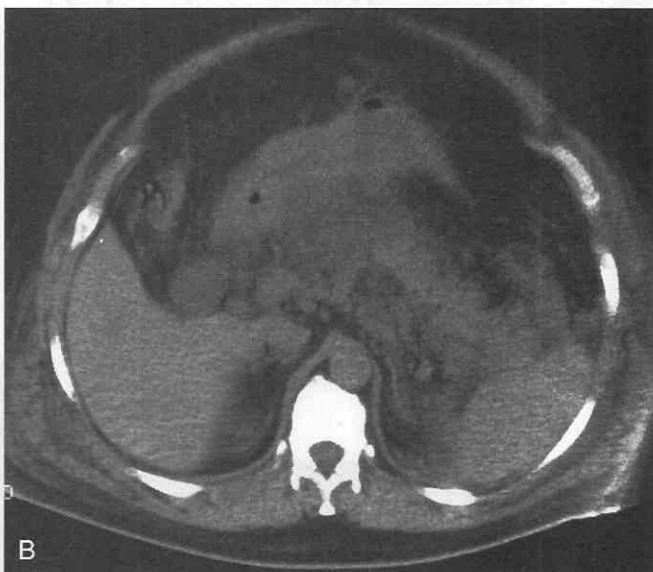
A, CT scan taken early in the patient's disease shows mild edema around the gland. B, Later scan shows increased edema between the head of the pancreas and the stomach. C, After a number of days, the inflammatory fluid coalesced into a pseudocyst (*arrow*).
